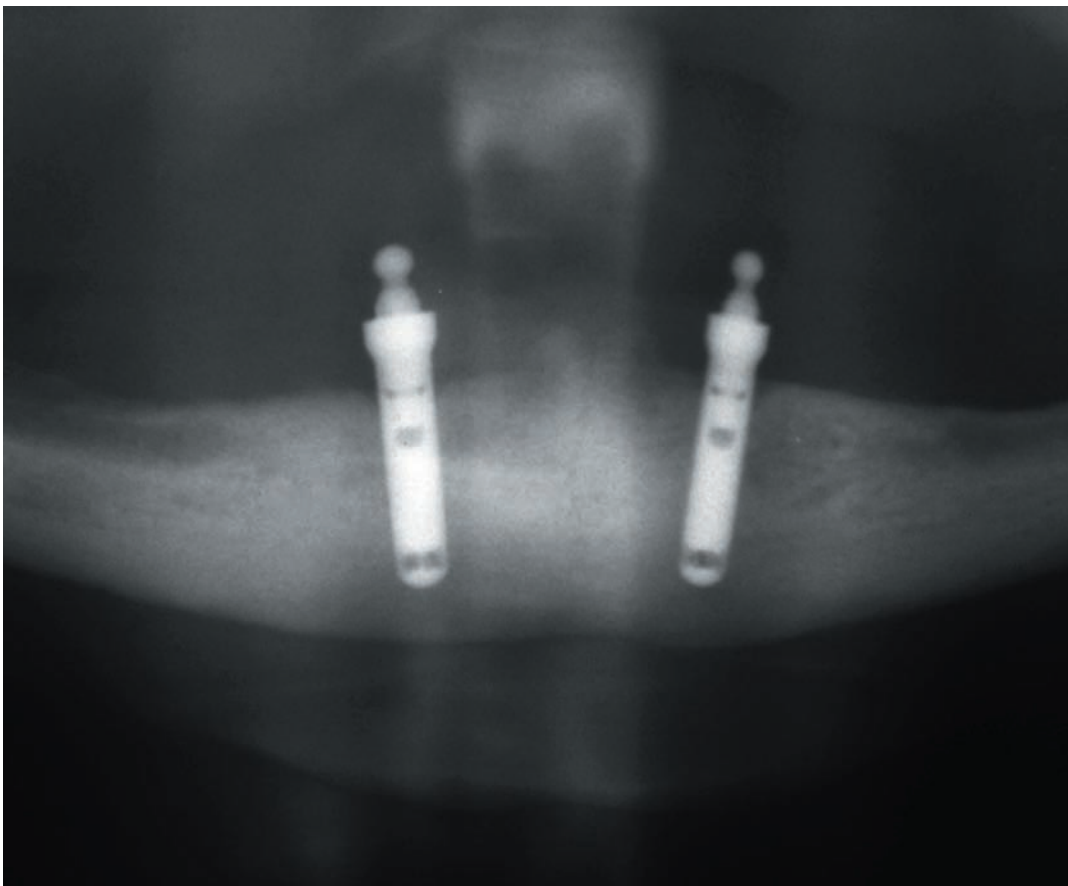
Panoramic radiograph taken at the last recall visit, four years later. Fixed reference points are indicated with arrows.
